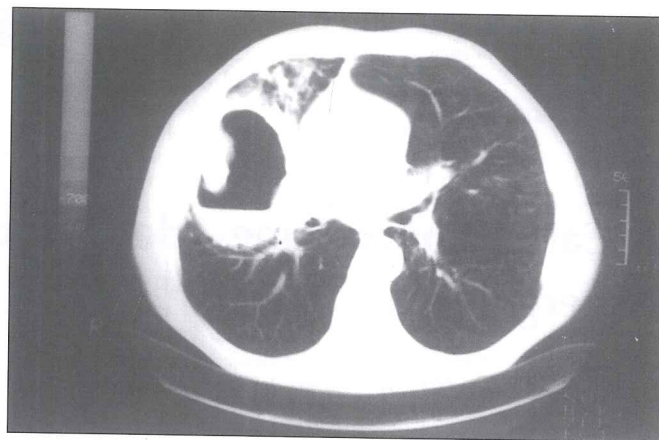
Computed tomographic scan shows an intracavitary mass surrounded by air crescent.
